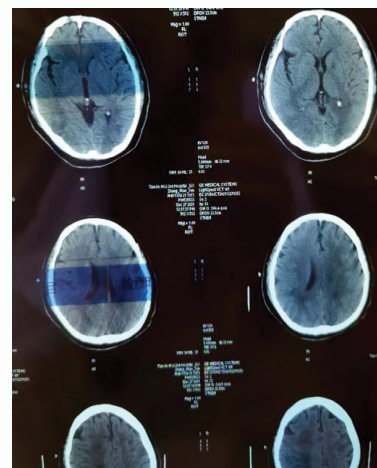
Brain CT showed acute ischemic infarction in bilateral frontal, parietal, occipital and paraventricular lobes.
